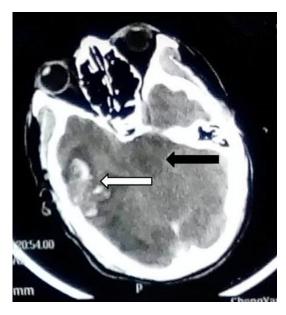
Brain CT scan in the local hospital showed the right temporal lobe hemorrhage (white arrow) and the cisterna ambiens was compressed severe (black arrow), then decompressive craniectomy was performed.
